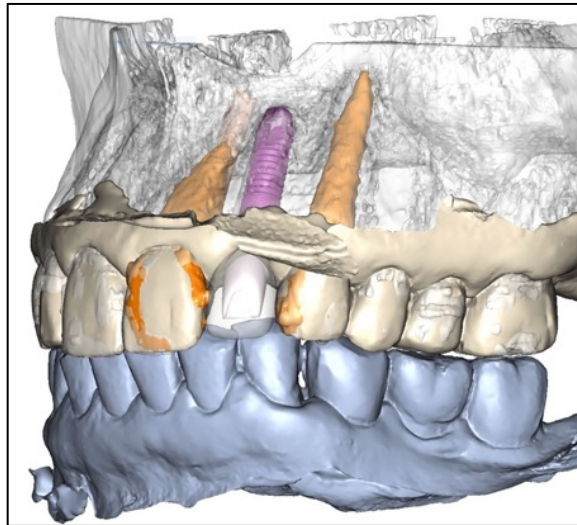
CBCT showing the planned implant location and restoration. Fabrication of the custom surgical guide will factor osseous anatomy, nerves, and root proximity.
